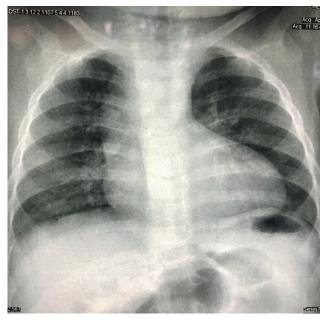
X-ray chest showed boot shaped heart "coeur en sabot" (apex lifted up with concavity in the region of pulmonary artery and oligemic lung)
